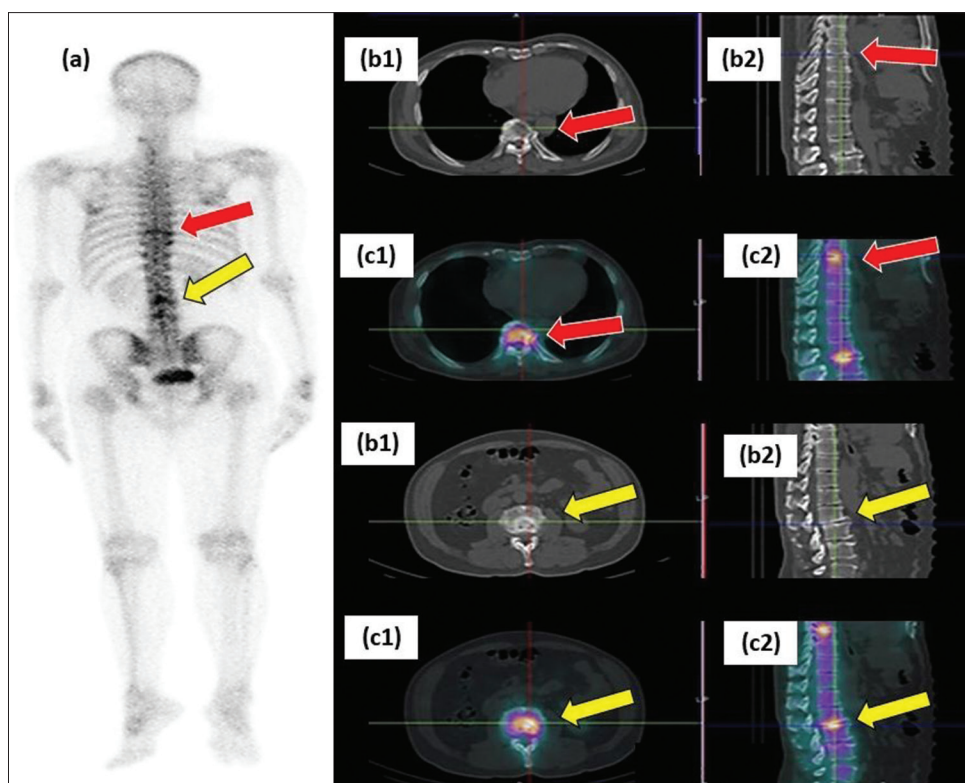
A 64-year-old man with lumbar pain and underlying bladder carcinoma. (a) Planar WBS revealed foci of increased tracer uptake at T8/T9 (red arrow), L2/L3 (yellow arrow) and L3/L4 vertebrae, corresponding to spinal osteoporotic DJD as seen on CT (b1, b2). (c1, c2) Fused SPECT/CT images demonstrating the DJD at T8/T9 (red arrow) and L2/L3 (yellow arrow), respectively. WBS: Whole-body bone scanning, SPECT/CT: Single photon emission computed tomography/computed tomography, DJD: Degenerative joint disease
